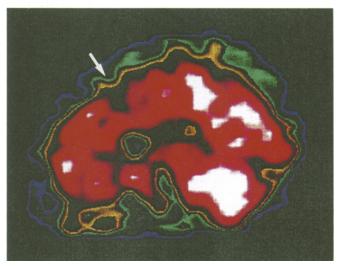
SPECT examination on 13 June 1991 showing focal hypometabolism in the region of the left lobulus paracentralis: frontal section (a) and parasagittal section (b): at the lobulus paracentralis level. In the supine position, the patient was injected intravenously with 20 mCi of freshly prepared  $^{m99}$ Tc HMPAO and imaged 30 min later with a GENESYS ADAC gamma camera interfaced with a PEGASIS ADAC computer. Acquisition parameters: 64 projections.  $64 \times 64$  matrix. 25 s per projection. Slice thickness: one pixel or 5 mm
